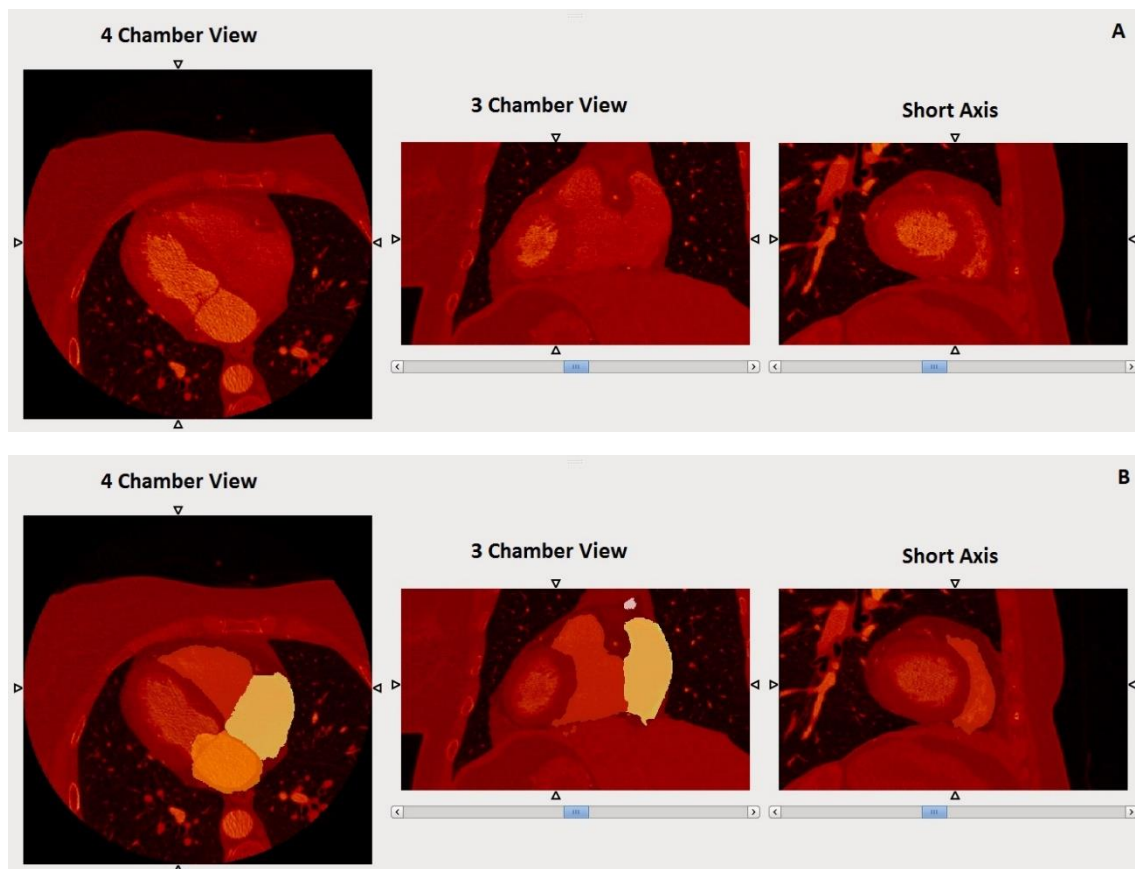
Atlas based cardiac segmentation technique's results, on selected CTA data (A –Original CTA image; B – Original CTA Image + Cardiac Segmentation)
